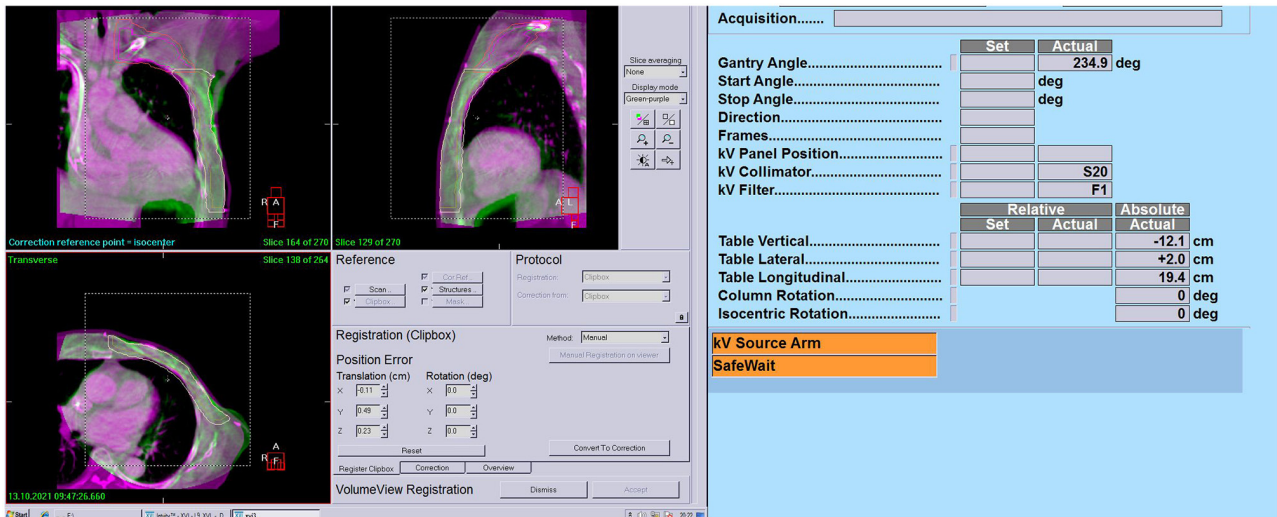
Cone beam CT alignment analysis. The main regions of interest are chest wall, upper and lower clavicle, vertebral body, and heart. Lat, lateral; long, longitudinal; vert, vertical; rot, Z axis rotation Angle.
